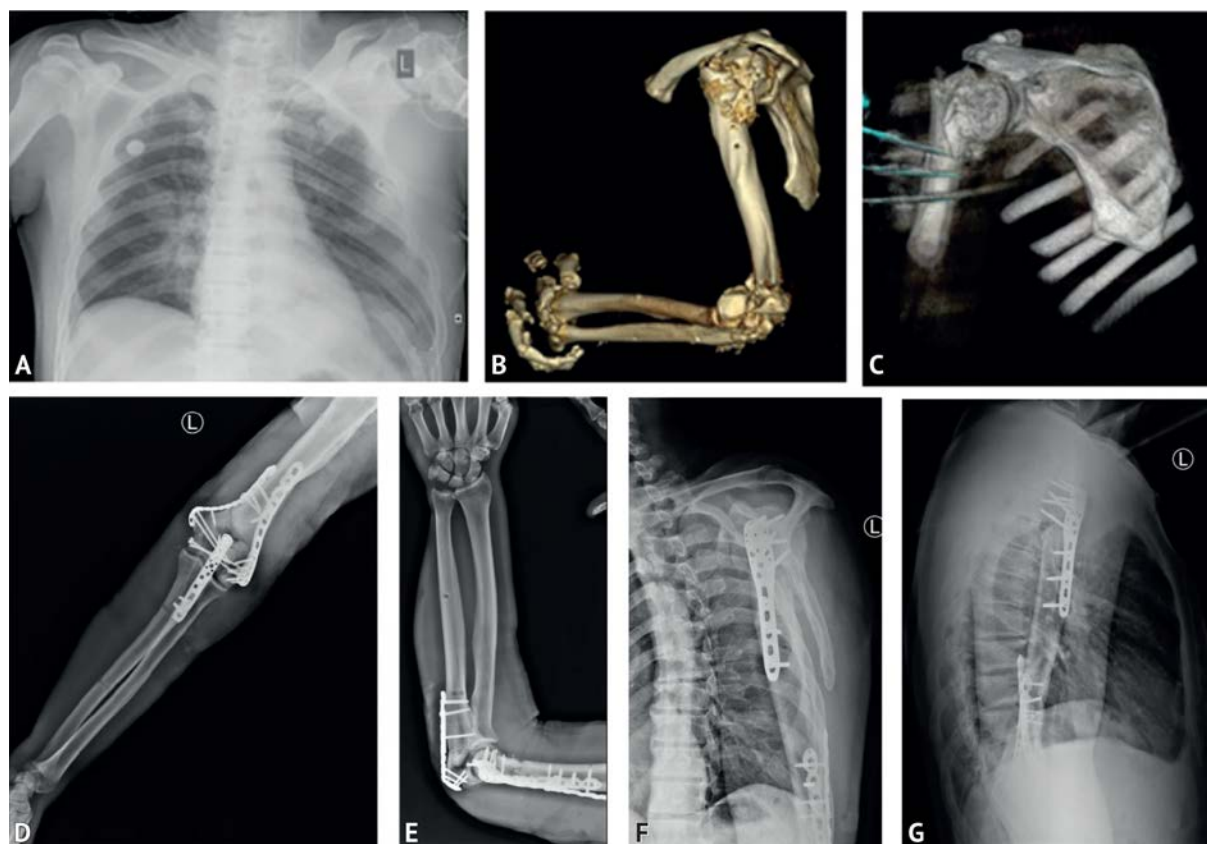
A — chest X-ray. In the lower lateral section on the left, an inhomogeneous shadow with an indistinct contour is determined, most likely diffuse intrapulmonary hemorrhage, positive dynamics; B, C — multifragmented surgical neck fracture, and in the lower third of the humerus with displacement of the fragments; D–G — condition after extraosseous and transosseous metal osteosynthesis of fragments of the lower third of the radius, left olecranon and the surgical neck of the humerus
